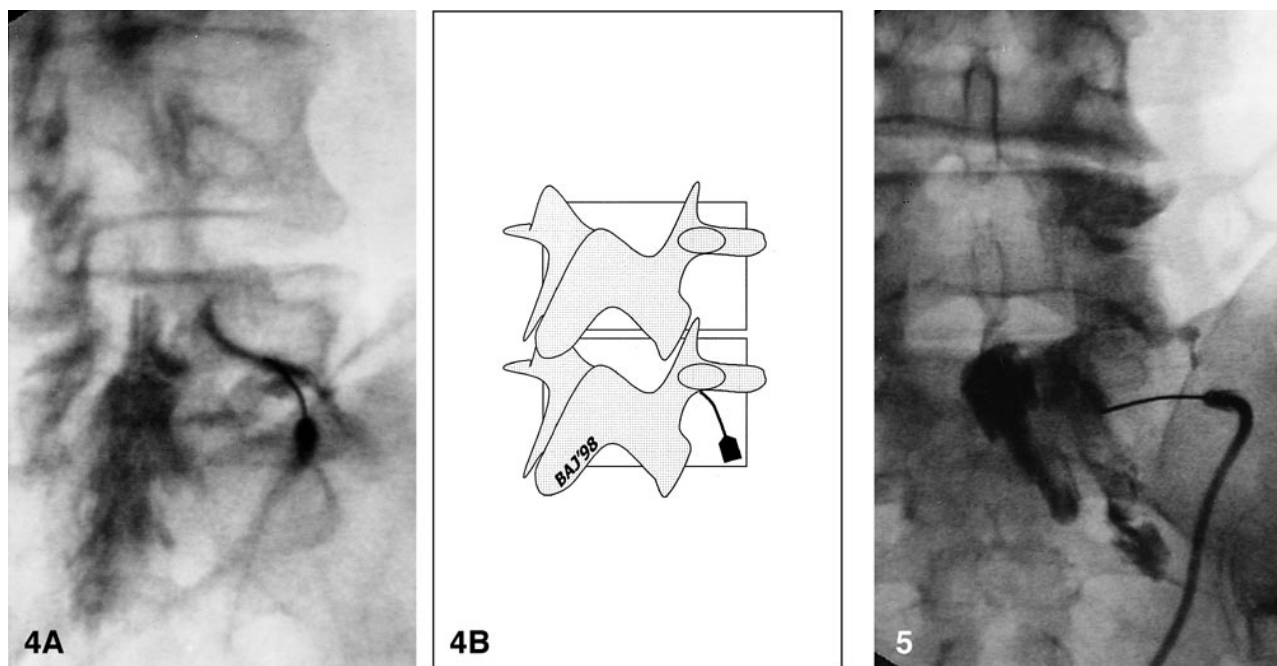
A, After sterile preparation and draping, a 22-gauge spinal needle is carefully advanced into the appropriate neuroforamen immediately subjacent to the vertebral pedicle via a dorsal/lateral approach using intermittent, brief (1–2 second), low-dose fluoroscopic checks. Oblique radiograph after contrast injection shows the needle tip within the right L5–S1 neural foramen. There is opacification of the proximal L5 nerve sheath, with epidural reflux of contrast material, which extends from the L4–L5 level to the S1–S2 level within the epidural space. Ideal needle placement produces opacification of the proximal nerve sheath and adjacent epidural space. After filming (anteroposterior, lateral, and/or oblique images), 2 to 3 mL of water-soluble steroid mixture followed by 3 to 5 mL of local anesthetic are injected through the same needle. Postinjection films are then obtained to document dispersal of the injectate.
